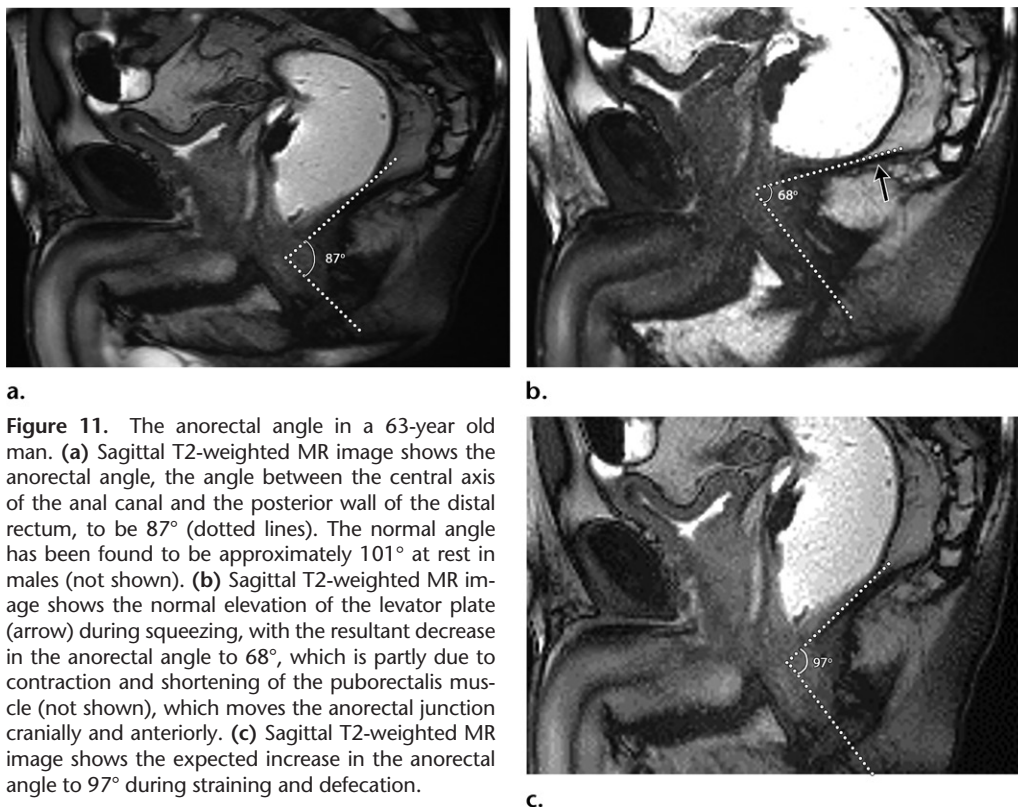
The anorectal angle in a 63-year old man. (a) Sagittal T2-weighted MR image shows the anorectal angle, the angle between the central axis of the anal canal and the posterior wall of the distal rectum, to be 87° (dotted lines). The normal angle has been found to be approximately 101° at rest in males (not shown). (b) Sagittal T2-weighted MR image shows the normal elevation of the levator plate (arrow) during squeezing, with the resultant decrease in the anorectal angle to 68°, which is partly due to contraction and shortening of the puborectalis muscle (not shown), which moves the anorectal junction cranially and anteriorly. (c) Sagittal T2-weighted MR image shows the expected increase in the anorectal angle to 97° during straining and defecation.
